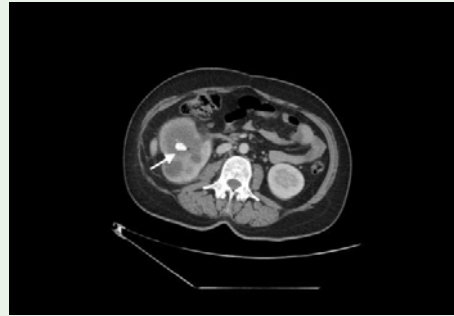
The abdominal computed tomography shows gas into right the renal parenchyma and a renal calculi (arrow).
